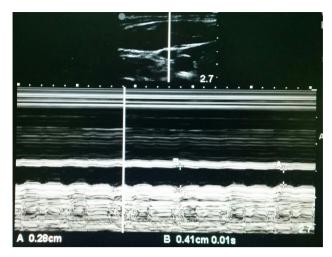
Ultrasound images of the internal jugular vein during respiratory cycle in B mode and M mode. IJV distensibility during respiratory cycle with minimum AP diameter (A) maximum AP diameter, (B) measured in M mode. A high variability of IJV internal diameter is seen.
